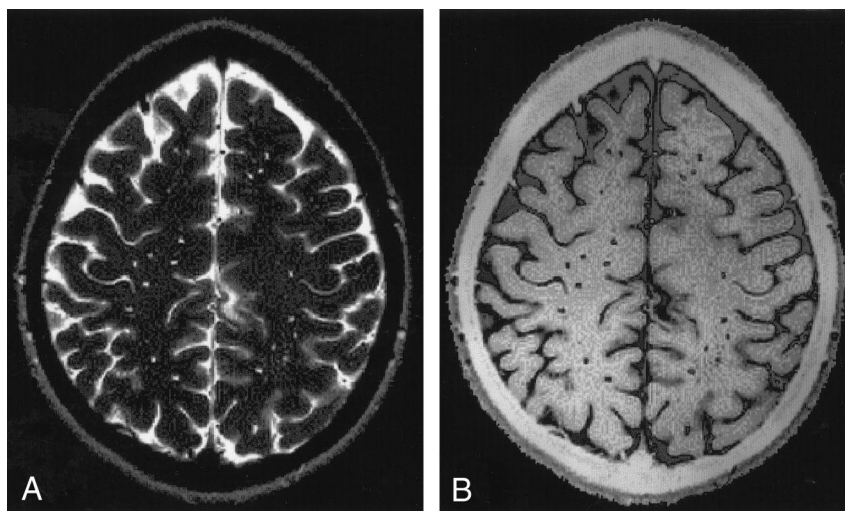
Consecutive axial high-convexity T2-weighted MR images (5500/128) show VRs. Image in A is most superior; image in D, most inferior.
